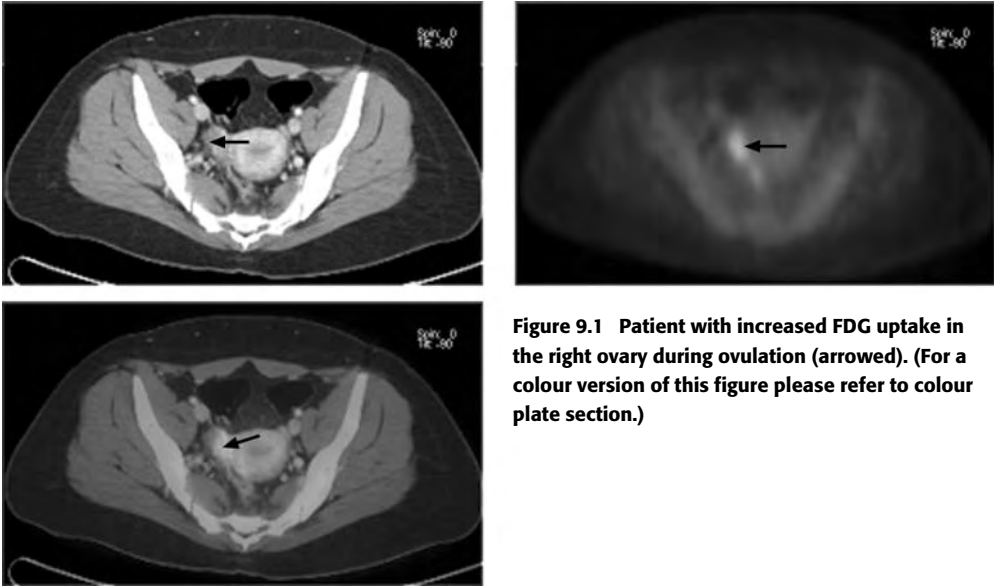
Patient with increased FDG uptake in the right ovary during ovulation (arrowed). (For a colour version of this figure please refer to colour plate section.)
